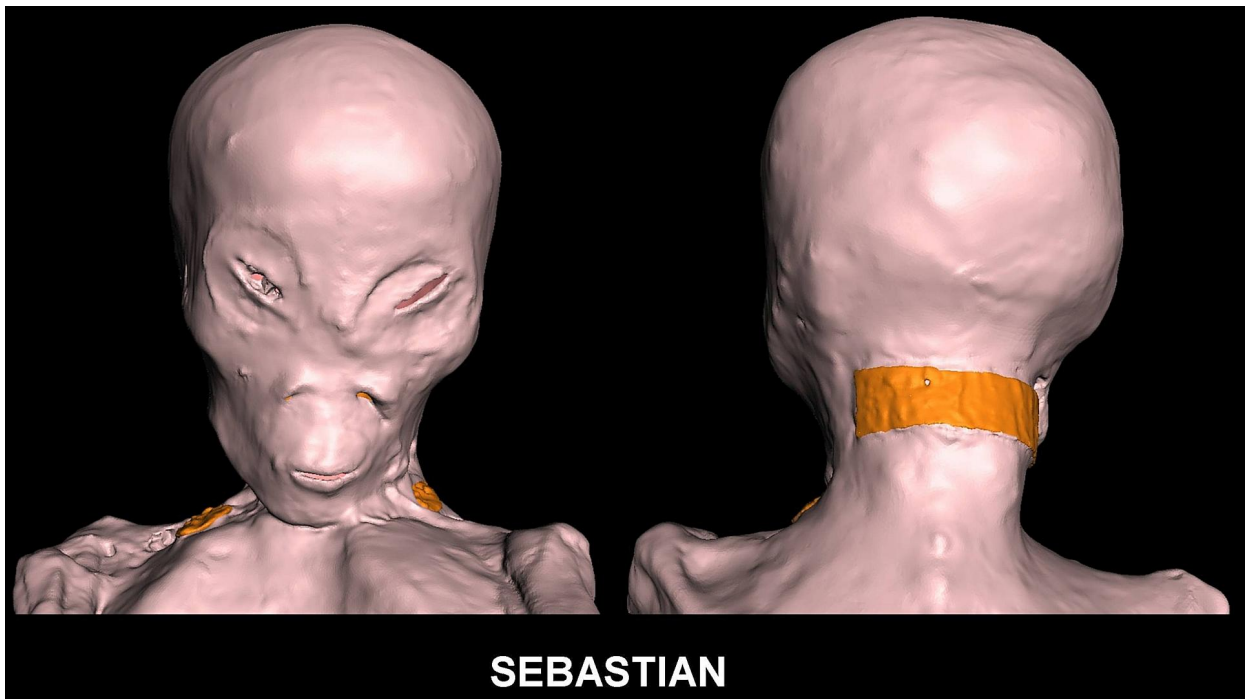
3D CT showing front and back view of head. Note the widely separated large slanting eyelids, inconspicuous nose, flat downward and medial pointing nostrils, small face, prominent jaws and small pointed chin. Tiny skin nodules were noted in scalp and right side of face. Metallic implants were shown in orange colour.
